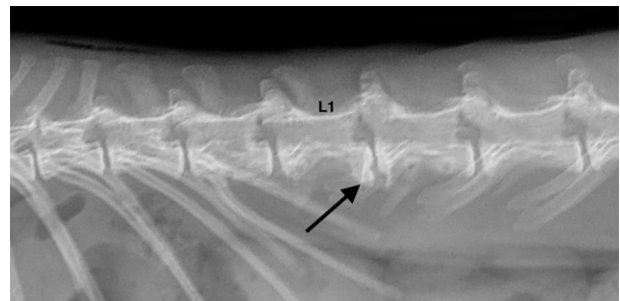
Lateral radiographic view of the thoracolumbar vertebral column 3 months after surgery showing complete healing of the fracture (arrow).
